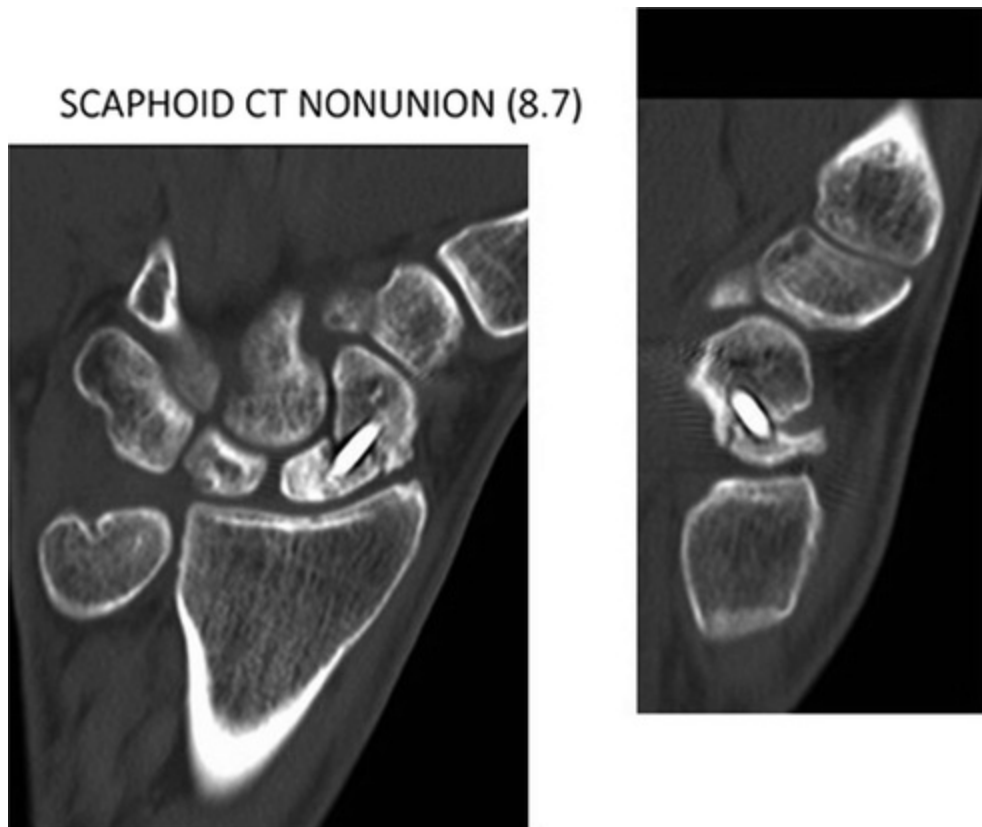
Computed tomography scan showing nonunion of a scaphoid waist fracture previously treated with screw fixation
